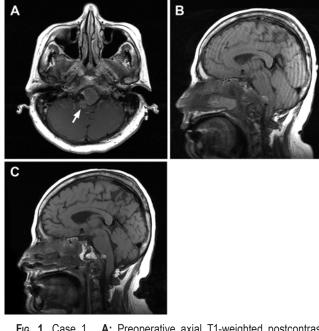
Case 1. A: Preoperative axial T1-weighted postcontrast MRI study showing a lobular clival mass significantly deforming the ventral medulla (arrow). B: Midline sagittal T1-weighted MRI study obtained on postoperative Day 7 with lumbar drain open demonstrating severe flattening of the pons against the clivus and sagging of the posterior fossa. C: Midline sagittal T1-weighted MRI study obtained after surgical reinforcement of the CSF leak, clamping of the lumbar drain, and resolution of symptoms demonstrating restoration of normal CSF spaces in the posterior fossa and basal cisterns.
